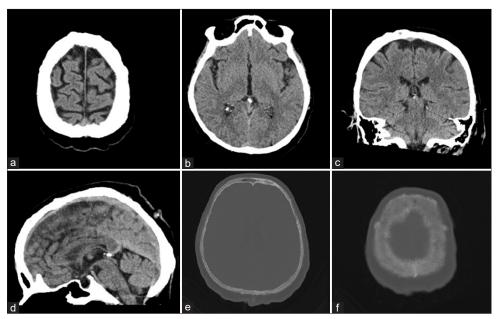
Non-contrast head computed tomography (CT) scan. (a and b) Axial slices at different levels showed no previous bone destruction, with clearly visible bone; (c and d) coronal and sagittal slices, respectively, showing no visible tumor; (e and f) CT scan bone window, axial slices at various levels showing well-formed bone with its diploic space, internal and external table.
